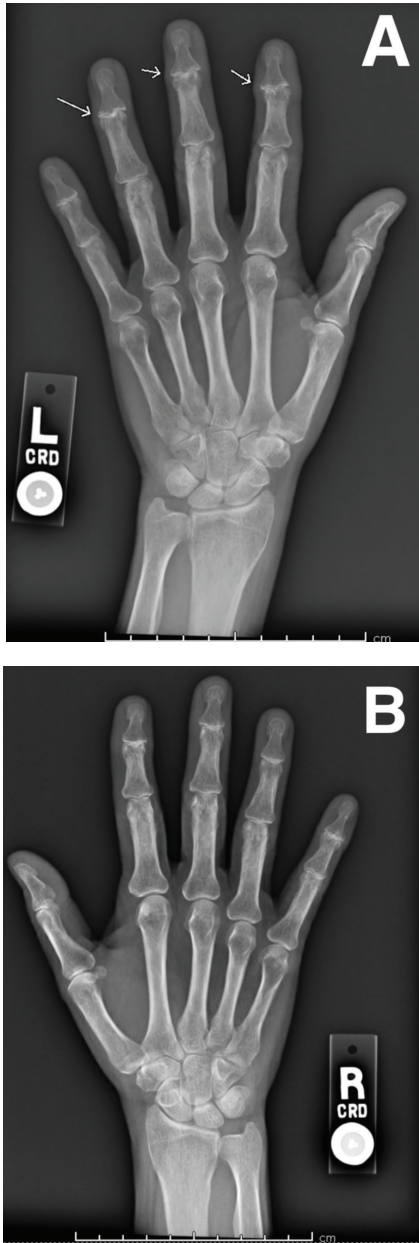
A radiograph of her left hand demonstrated narrowing of distal interphalangeal joints with central collapse or erosion of joint spaces with spur formation (a, arrows). A radiograph of her right hand demonstrated narrowing of the distal interphalangeal joints and minimal central collapse (b).
